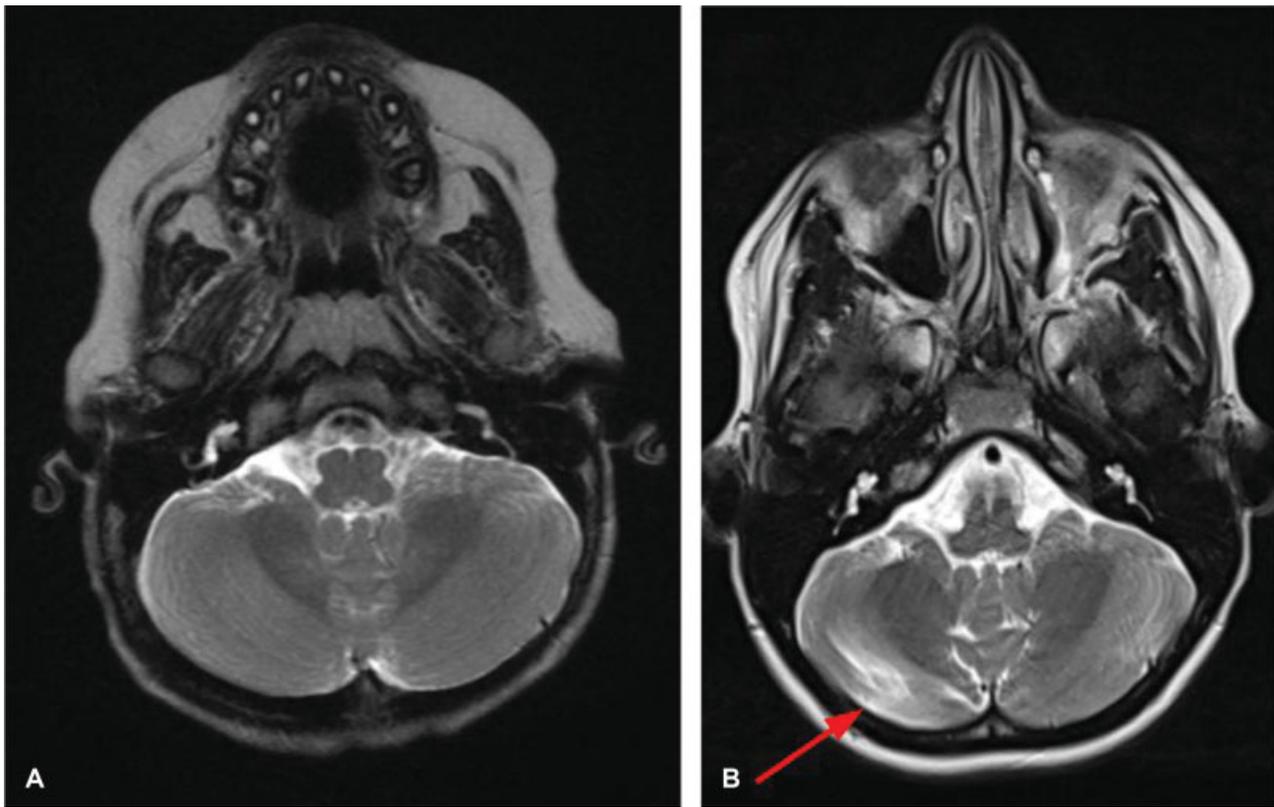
Axial T2-weighted MRI at (A) 21 months and (B) 11 years of age. The latter MRI shows a widening of the sulci of the right cerebellum, with gliosis, indicated by the arrow. MRI, magnetic resonance imaging.
